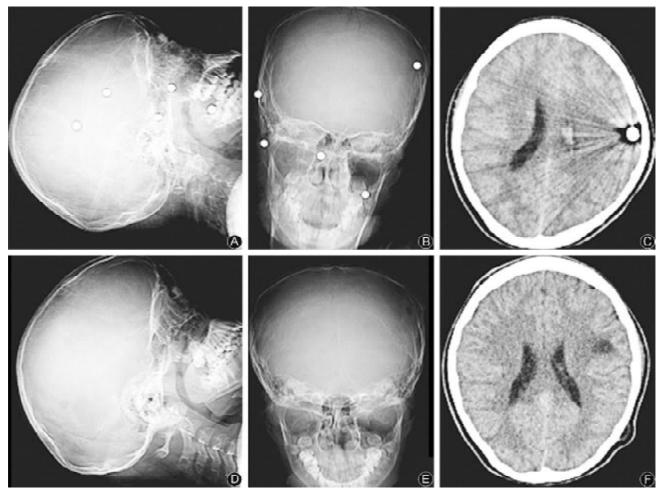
Preoperative CT scanograms showing ball bearings used in a suicidal bombing (A and B). Axial CT brain showing ball bearings in left parietal region with brain edema and intraventricular hemorrhage (C). Postoperative pictures after removal of ball bearings (D, E and F).
